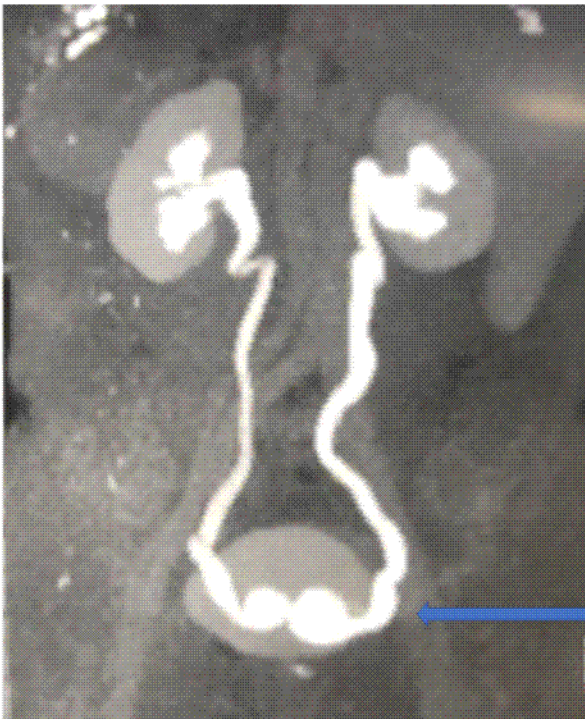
CT urography showing bilateral single system ureteroceles and showing the typical “Cobra-headed” appearance (Arrow).
